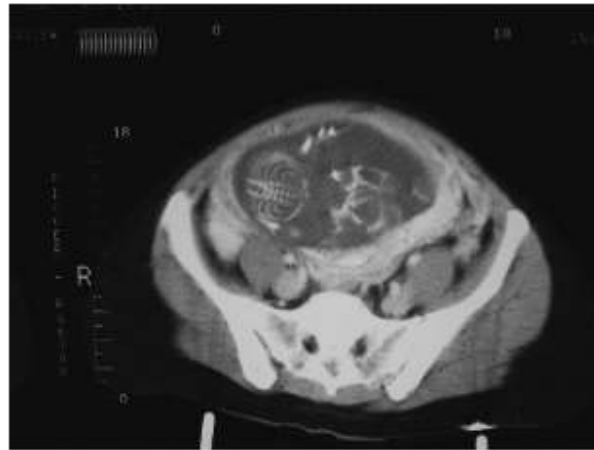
Abdominal computed tomography (CT) scanning in a pregnant woman. (From Dr Patrizio Petrone's personal archives.)
